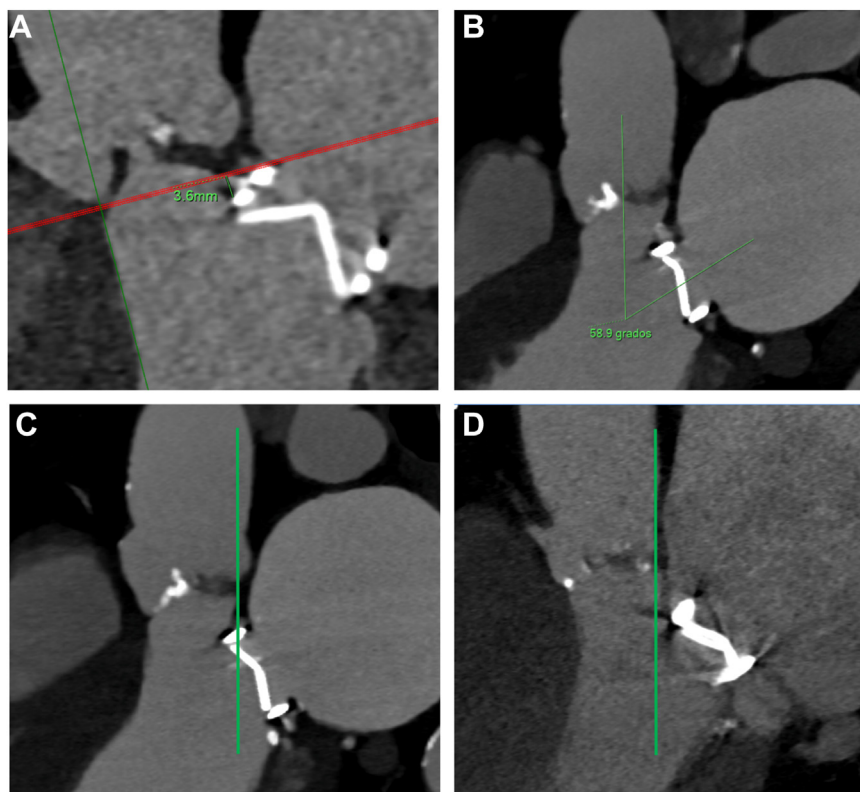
Preprocedural computed tomography images in patients with previous mitral prostheses. (A) Mitroaortic distance (distance between the aortic annulus and the mitral prosthesis). (B) Angle between the mitral prosthesis and aortic valve planes. Line perpendicular to the mitral side of the aortic annulus to delimit protrusion (C) or not (D) of the mitral prosthesis housing toward the left ventricular outflow tract.
